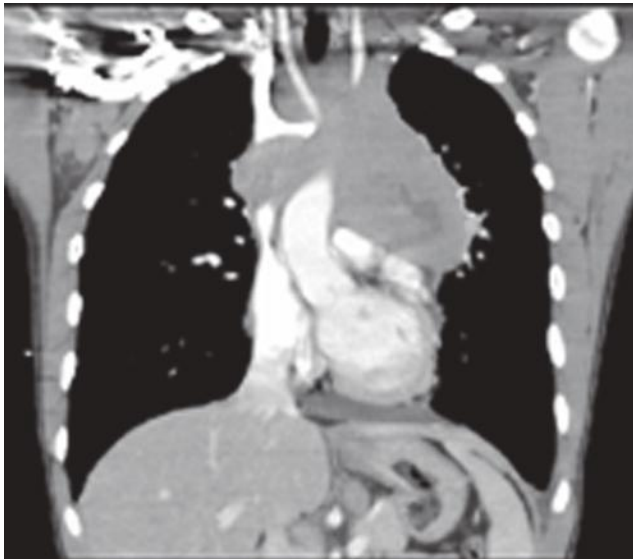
Computed tomography scan of child with mediastinal lymphoblastic lymphoma.
